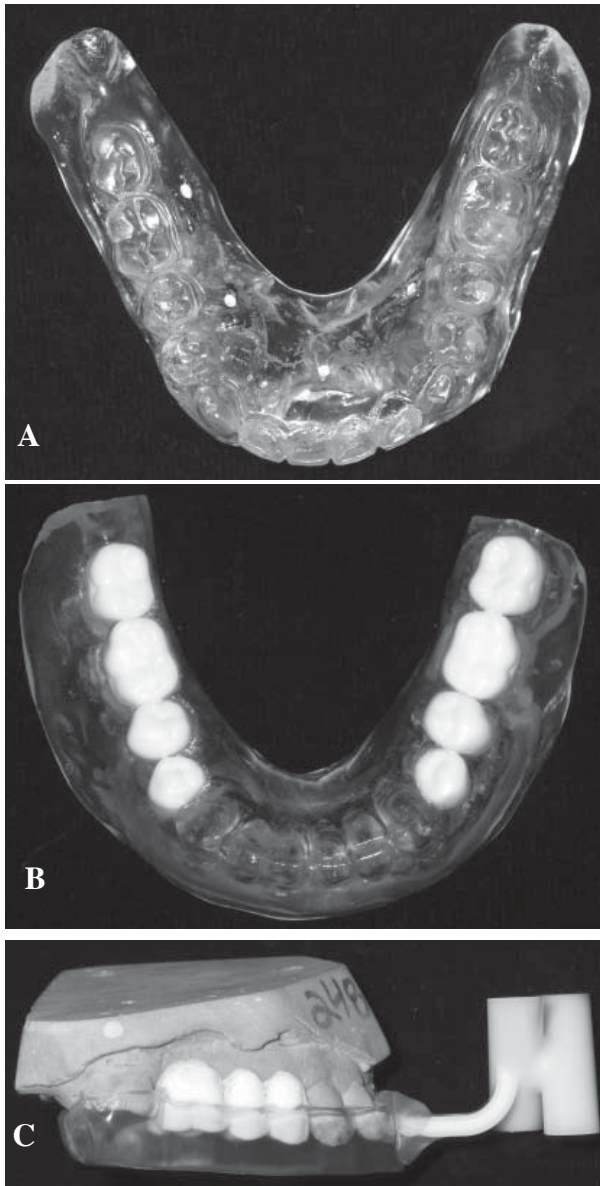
Examples of scan prostheses. A. NobelGuide™ Radiographic Guide, B. Siplant® scan prosthesis, C. EasyGuide™ scan prosthesis.
